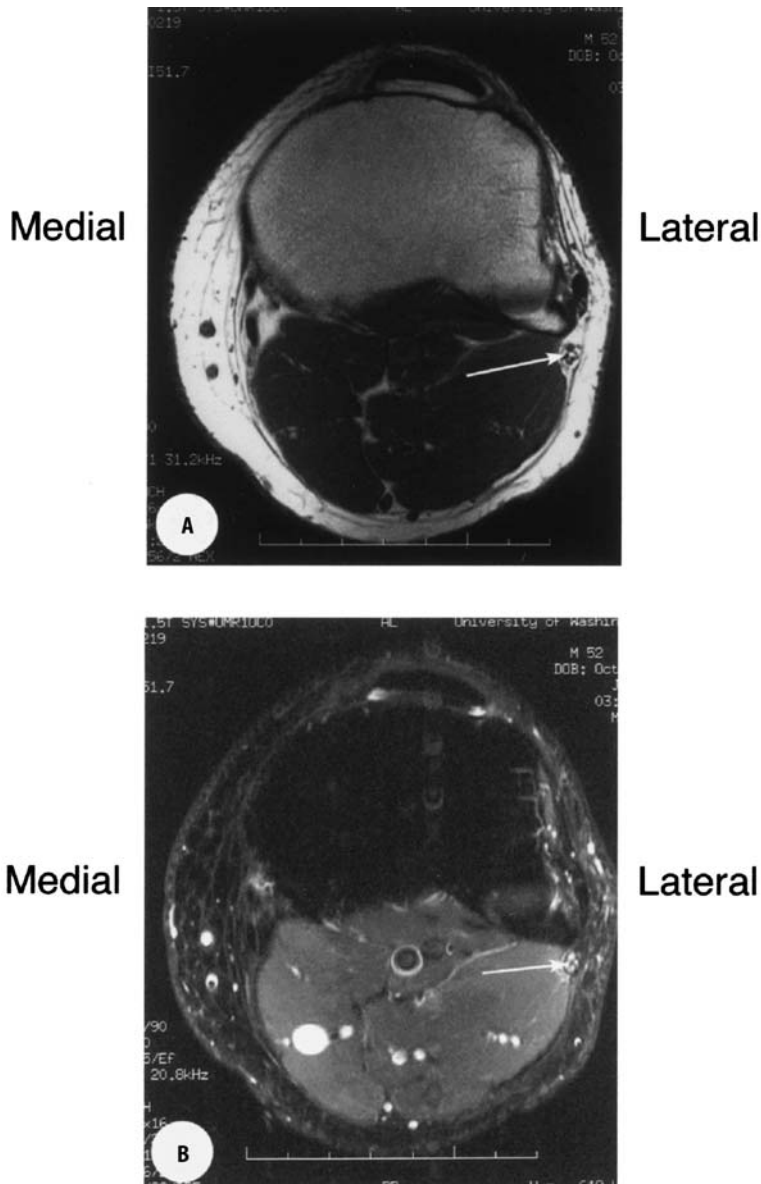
Axial MR images through the lower extremity at the level of the fibular head in a patient with a traumatic peroneal neuropathy. The T1-weighted sequence a visualizes the common peroneal nerve, surrounded by fat (white arrow). This nerve was found to display increased signal on the STIR sequence image b (from [13]).
